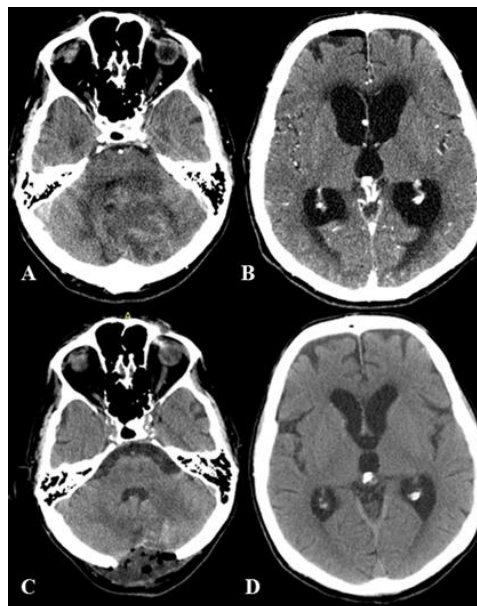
CT image of cerebellar metastasis: A/ tumor formation affecting the vermis and the cerebellar hemispheres, predominantly on the left; the 4th ventricle and posterior fossa subarachnoid spaces are compressed; B/ CT image of obstructive hydrocephalus in the same patient; C/ Postoperative CT demonstrates total tumor removal with decompression of the 4th ventricle and posterior fossa subarachnoid spaces; D/ considerable reduction of the hydrocephalus
